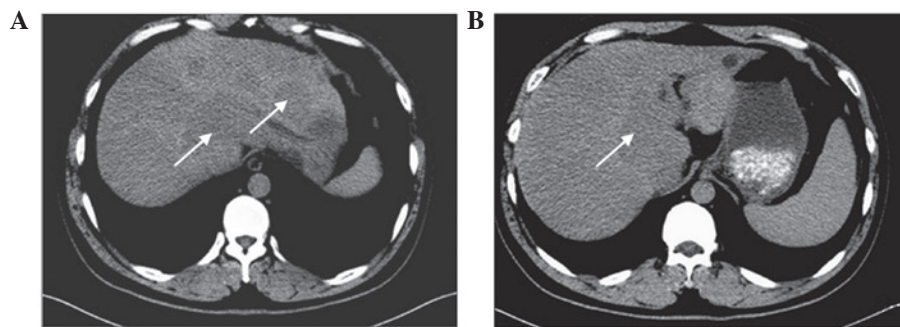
Computed tomography (CT) findings of primary liver leiomyosarcoma. (A) Plain CT showing slightly low-density lesions (white arrow) with definite borders in the caudate and left lobes of the liver. (B) lower scan slice revealing a definite tumour border.
